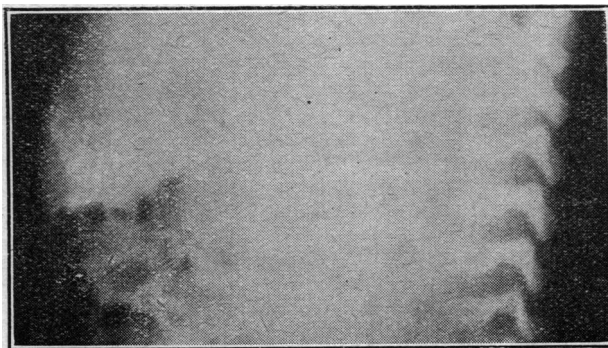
Case 2. Radiograph taken aged 7 weeks, showing calcification of parietal peritoneum.
